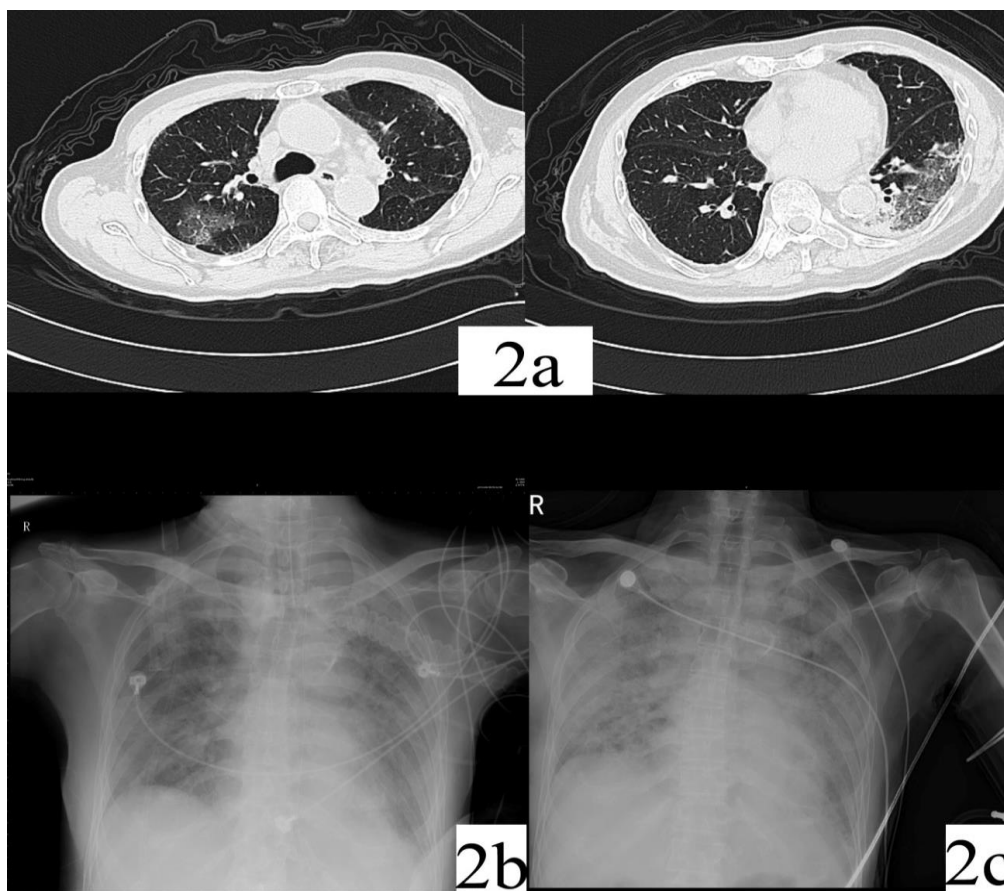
Images of the 2nd case: (a) HRCT showed multiple bilateral ground-glass opacification. (b) Chest X-ray showed extensive bilateral ground-glass opacification. (c) Chest X-ray revealed diffuse bilateral air-space consolidation
